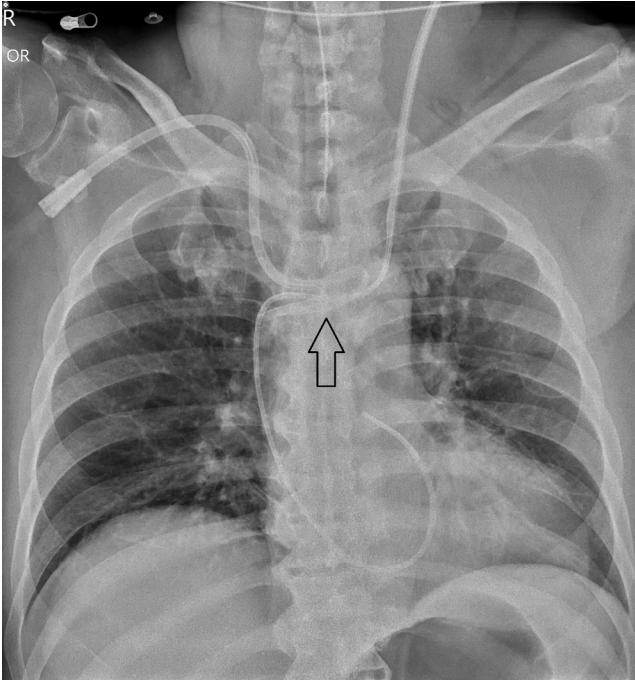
Intraoperative chest radiograph after Swan-Ganz catheter insertion. The mid to distal portion of Perm catheter was positioned in the left brachiocephalic vein, with a flexure in the middle and the tip in superior vena cava (black arrow).
